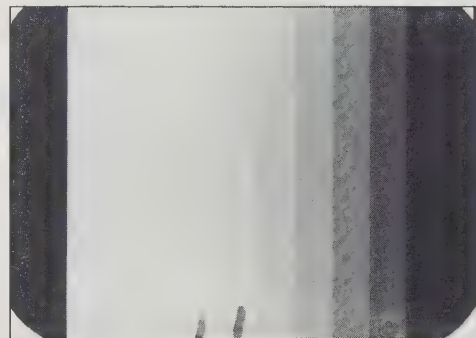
Radiographs of aluminum stepwedge.
